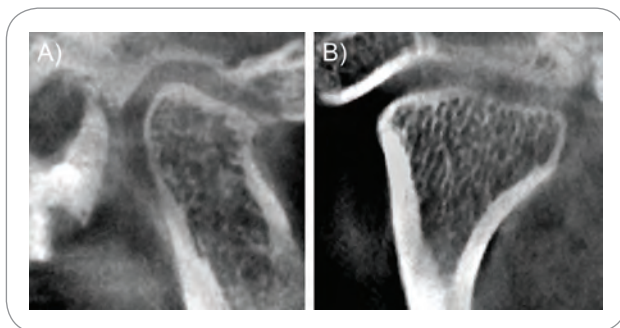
Bone remodeling on lateral (A) and coronal (B) CBCT sections showing flattening and cortical thickening of the antero-superior surface of the condylar head and glenoid fossa.
